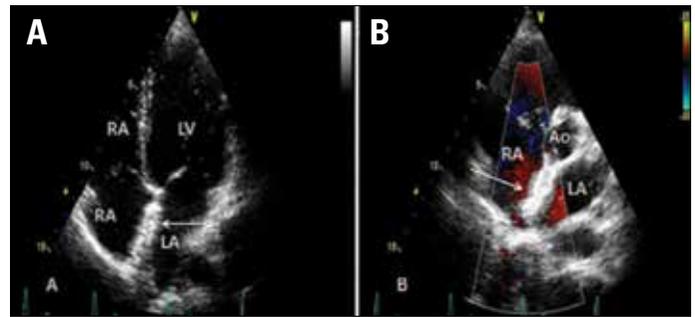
Transthoracic echocardiographic images of the septal occluder device (arrow) after implantation. (A)-apical 4 chamber view (B)- parasternal short axis view
